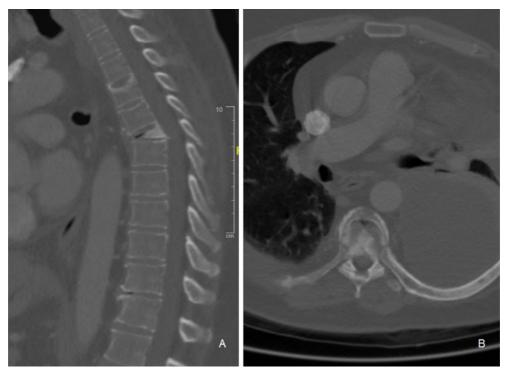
Chest CT scan showing large left-sided pleural effusion, as well as T4 and T6 compression fractures.
